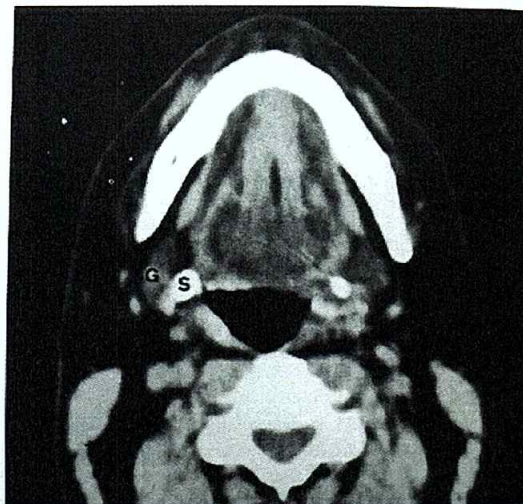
CT scan showing lateral displacement of right submandibular gland (G) by the calcified stylohyoid ligament (S)
